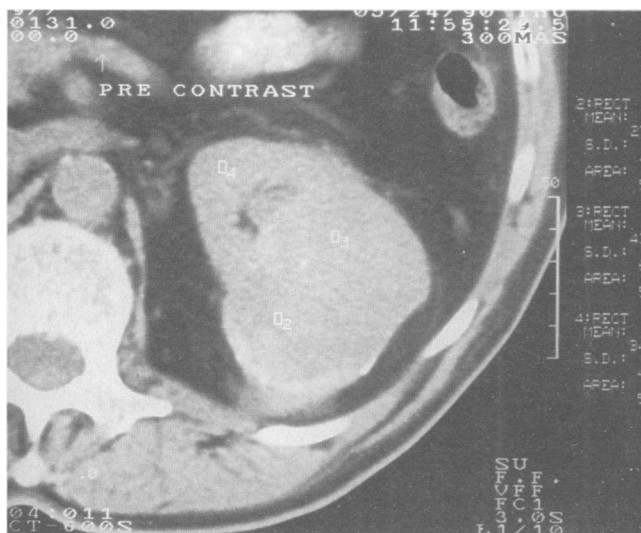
Noncontrast-computed tomographic scan through a left renal mass lesion (O₂ and O₃) is shown.
